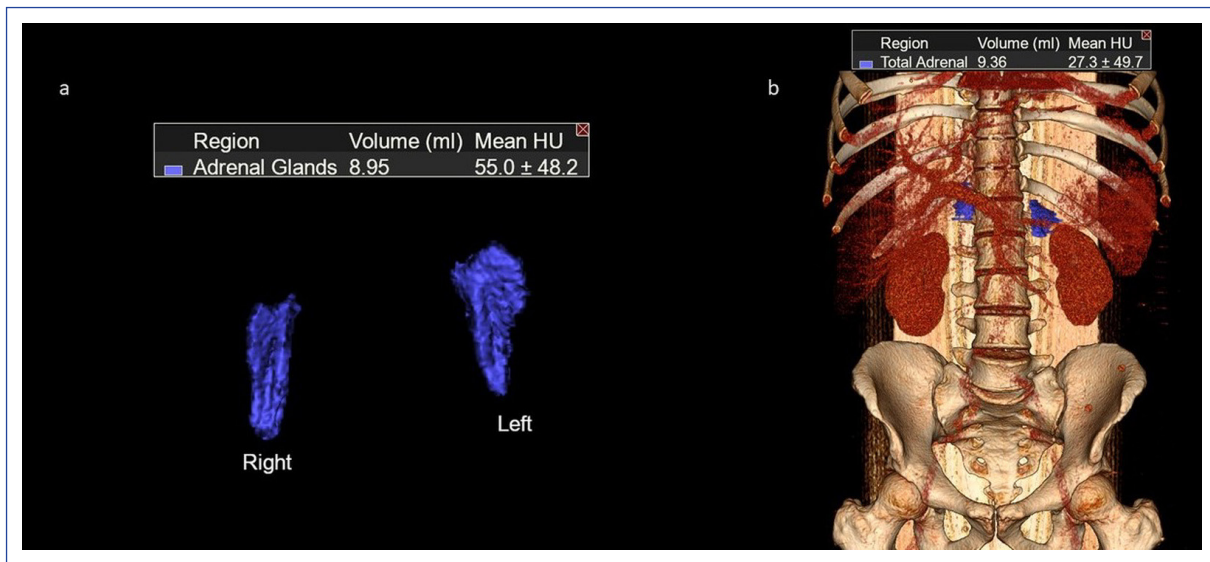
(a and b) Calculation of adrenal glands volume and three-dimensional reconstructed CT image of its.
